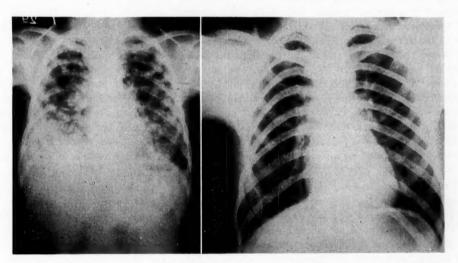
Contrast in chest x-rays taken before therapy and eighteen years later.
